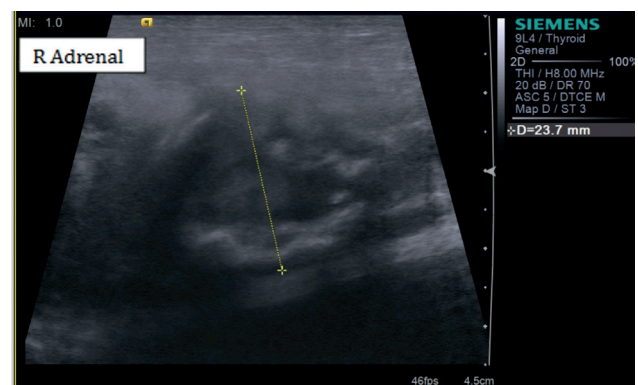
Adrenal masses may be detected as an incidental finding on abdominal ultrasound.
